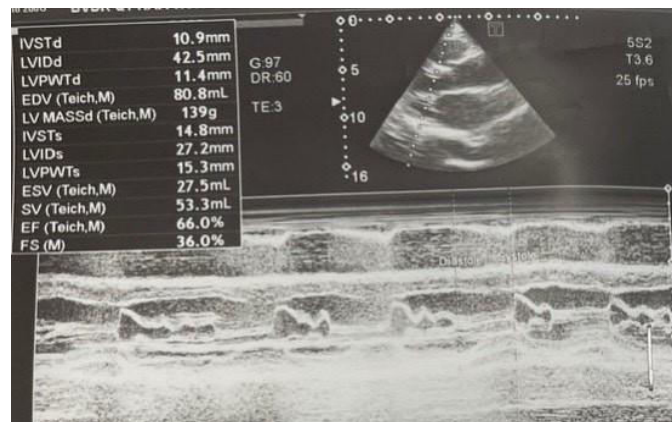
Echocardiogram Doppler 8/2023: Left ventricular ejection fraction (EF): 66%, Mitral regurgitation grade 2/4, aortic regurgitation grade 2/4, tricuspid regurgitation grade 3/4.
